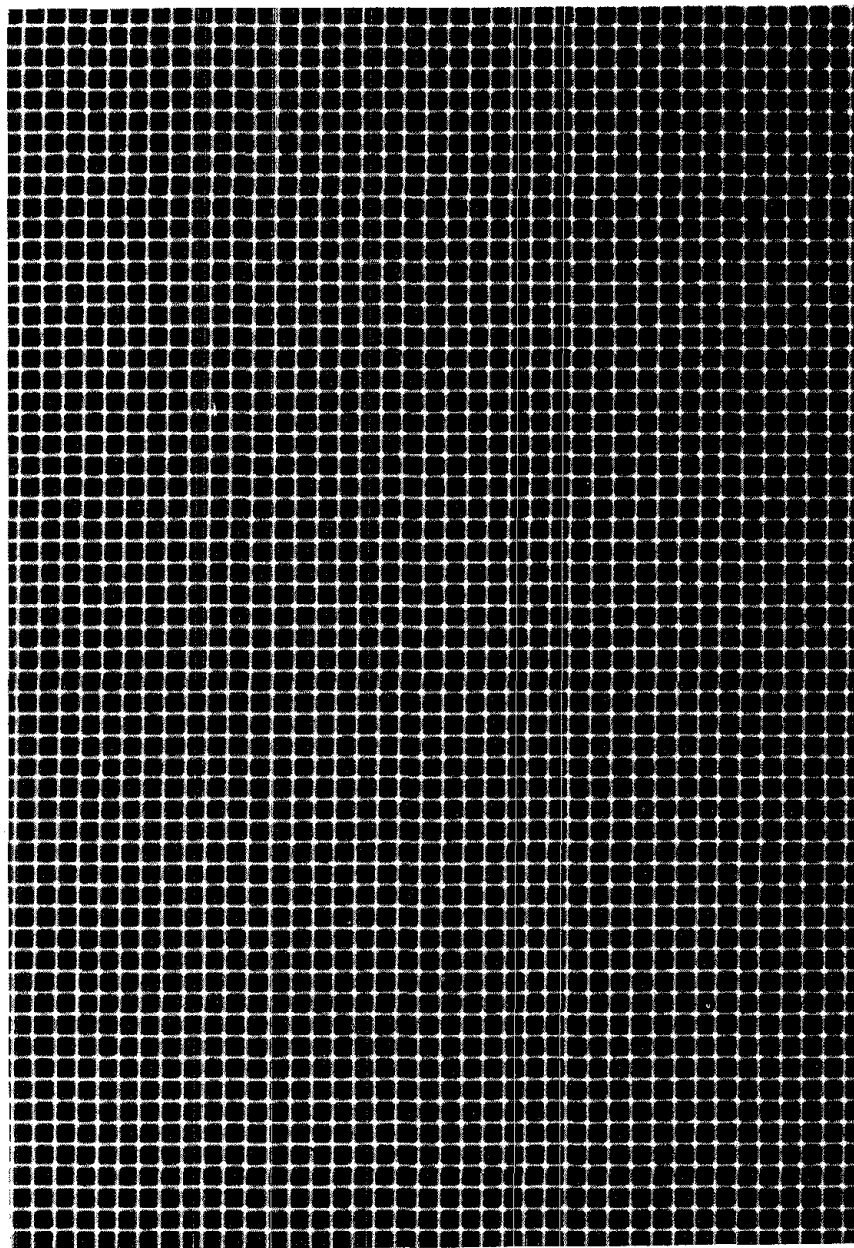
Wire mesh radiograph, good screen contact.
